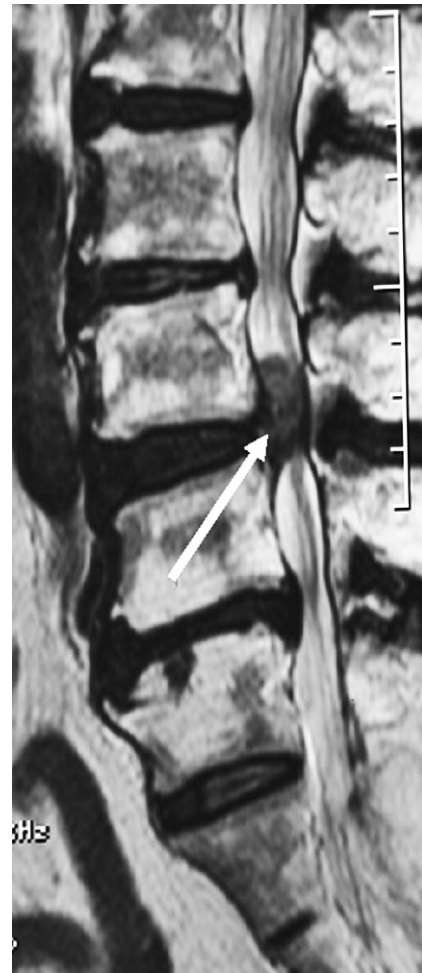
Spinal magnetic resonance imaging in Case 1 demonstrates a huge compressing lesion to the dural sac with marked cranial migration at the L3–L4 level on a T2-weighted sagittal image. Abrupt loss of continuity of the posterior longitudinal ligament is also noted (arrow).
